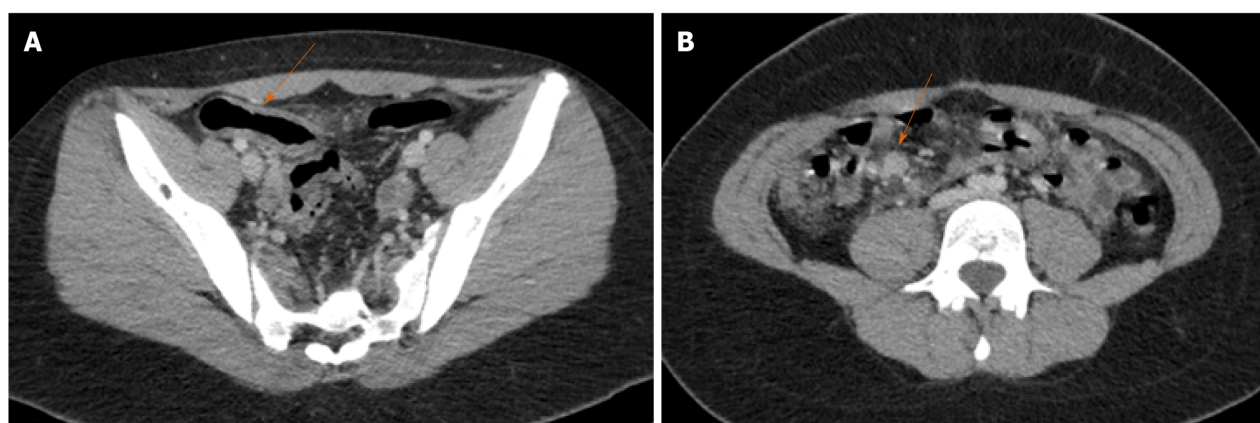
Terminal ileitis in the setting of multisystem inflammatory syndrome in a child. Axial images of a contrast-enhanced computed tomography of the abdomen and pelvis in a 13-yr-old female who presented with a 4d history of abdominal pain. A: There is wall thickening in the terminal ileum with adjacent fat stranding; B: Multiple reactive lymph nodes are seen in the right lower quadrant. Clinical and laboratory findings met criteria for multisystem inflammatory syndrome in children. Of note, the patient had tested positive for severe acute respiratory syndrome coronavirus-2 4 wk prior to presentation. The patient recovered after medical treatment including intravenous immunoglobulin, prednisone and dopamine.
